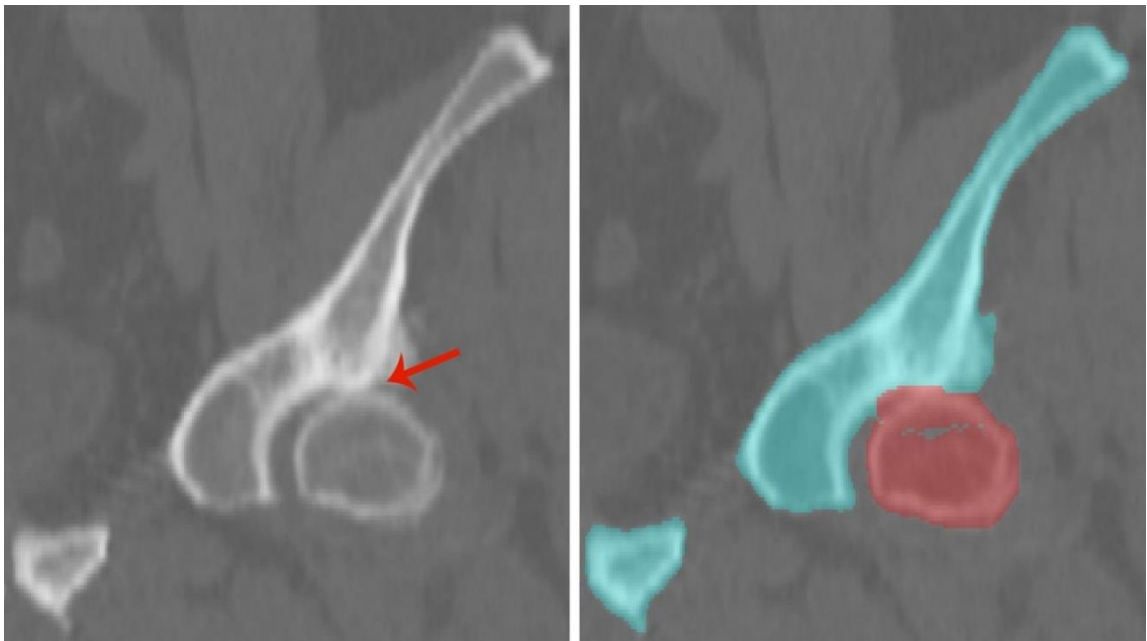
Coronal CT image of a dysplastic hip with a narrowed joint space (left). The attenuation values at this location are similar, making it difficult for the automated algorithm to accurately identify the bone edges in its segmentation (right).
